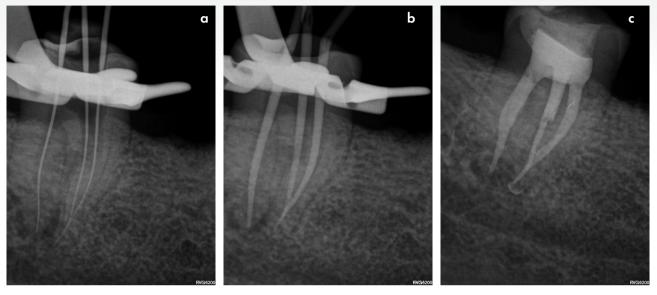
(a) All canals were negotiated to patency with a size 10 K-file, working length determined and a reproducible microglide path prepared; (b) Peri-apical radiograph confirming the fit of the ProTaper Ultimate Conform Fit Gutta Percha Points; (c) Final post-operative result after obturation
